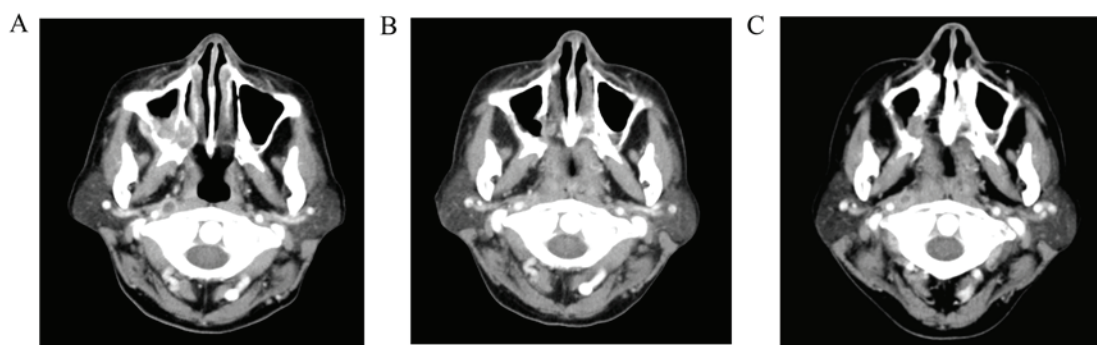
Contrast CT (before and after chemotherapy). (A) At the initial examination, (B) after 1 course of chemotherapy, there was a reduction in tumor size and (C) After 3 courses of chemotherapy, there was tumor regrowth.
